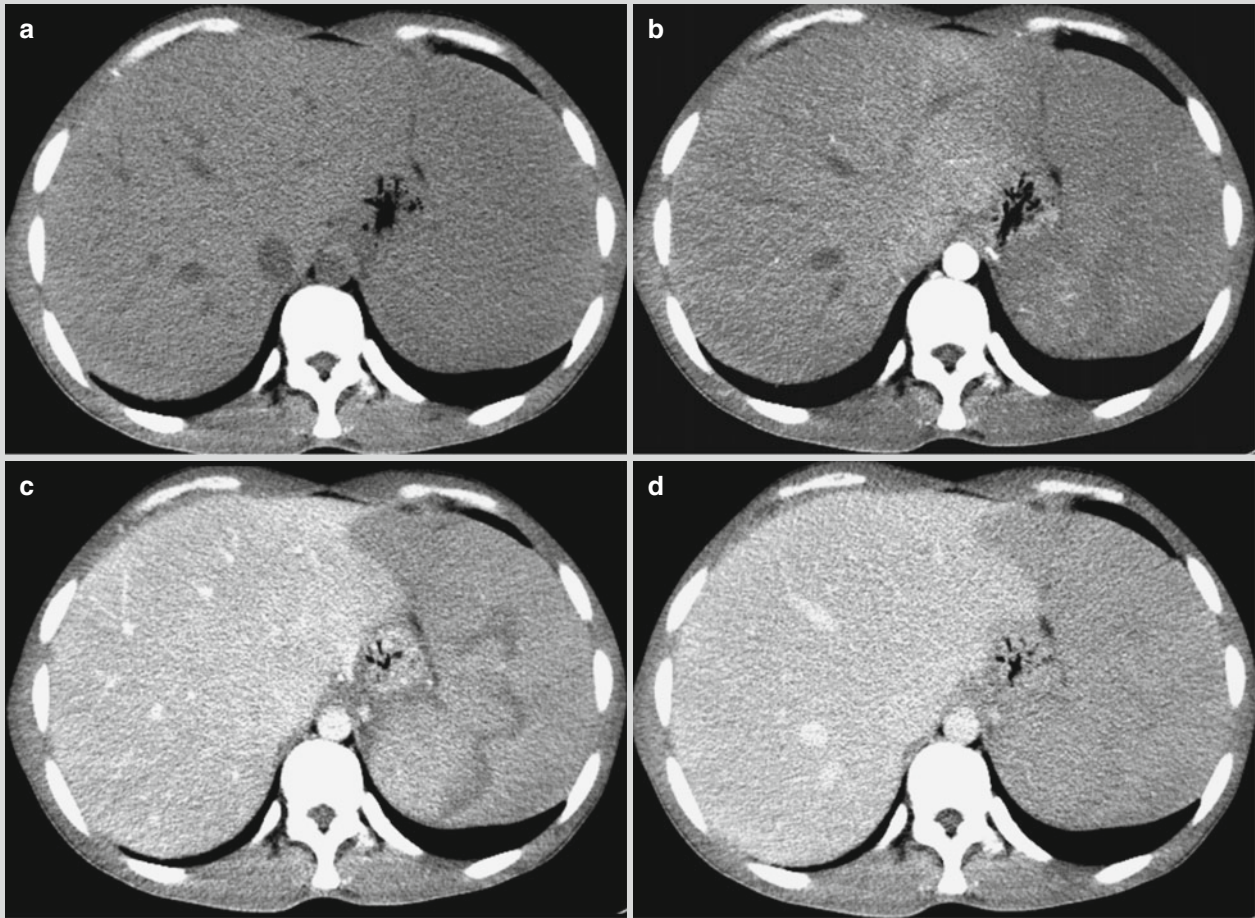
Abdominal malaria with hepatosplenomegaly and splenic infarction. (a) Plain CT scanning demonstrates increased volumes of the liver and the spleen. (b) Contrast CT scanning demonstrates irregular-shaped low-density area at the arterial phase in the spleen, with internal spots and flakes of slightly high-density shadows. (c) By
